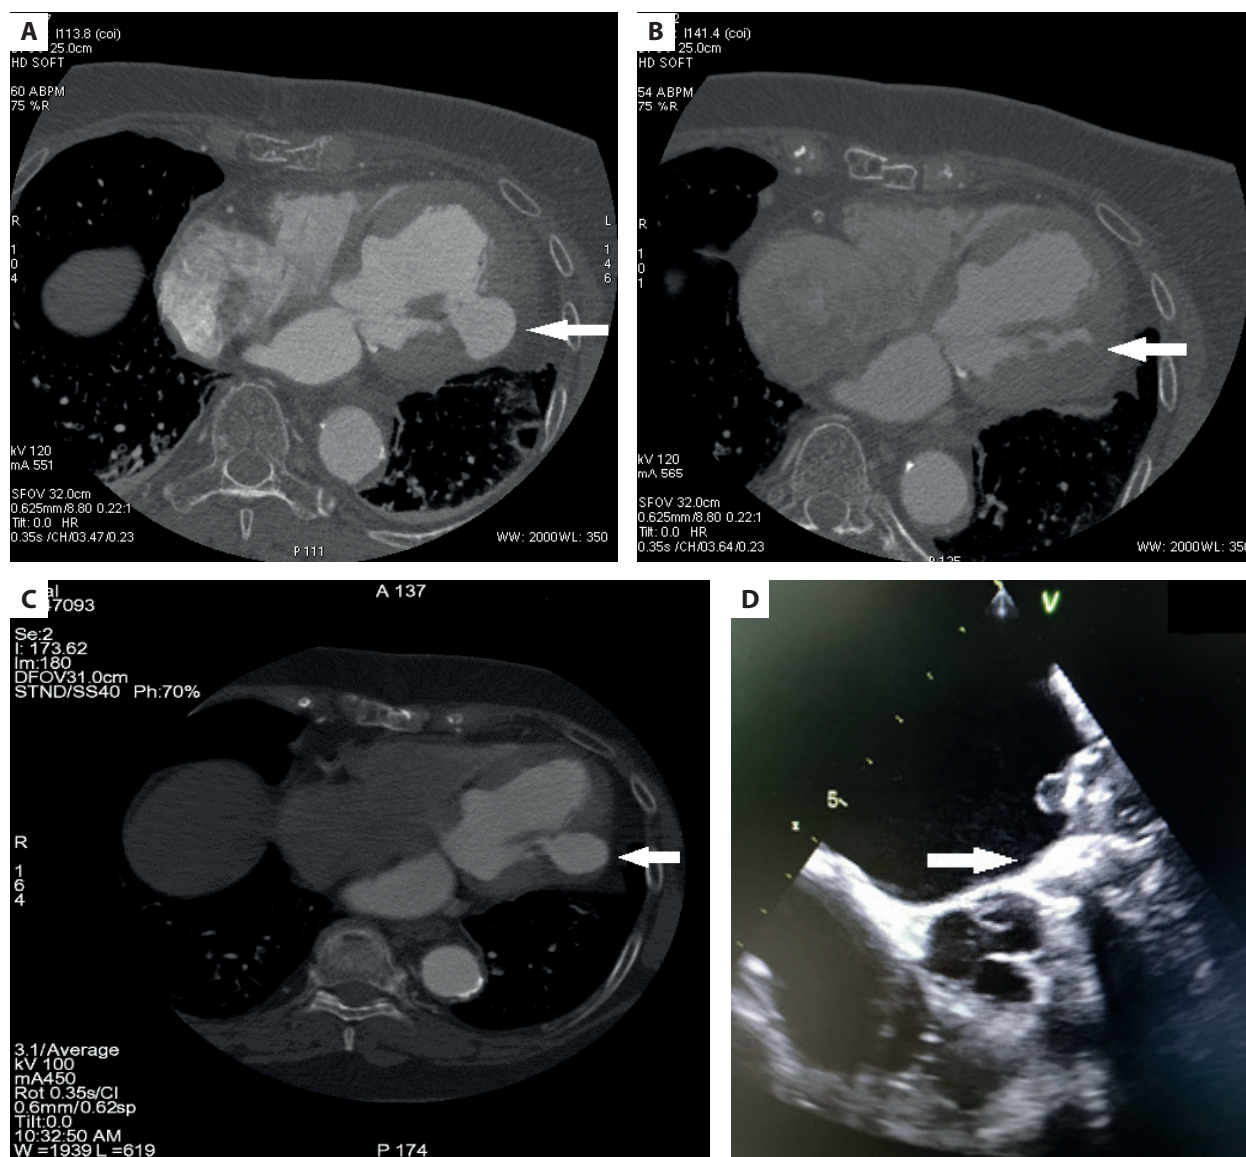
A. Cardiac computed tomography — left ventricular pseudoaneurysm. B. Cardiac computed tomography — partial thrombosis of the pseudoaneurysm. C. Cardiac computed tomography — recanalization of the pseudoaneurysm. D. Transesophageal echocardiography. The arrow indicates a thrombus adherent to the occluding device
